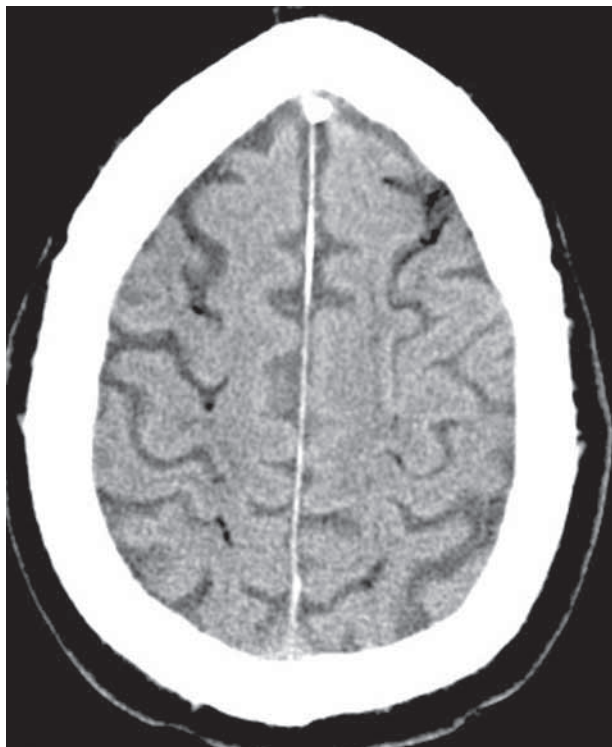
Noncontrast computed tomographic scan of the brain showing bihemispheric intracerebral air.
